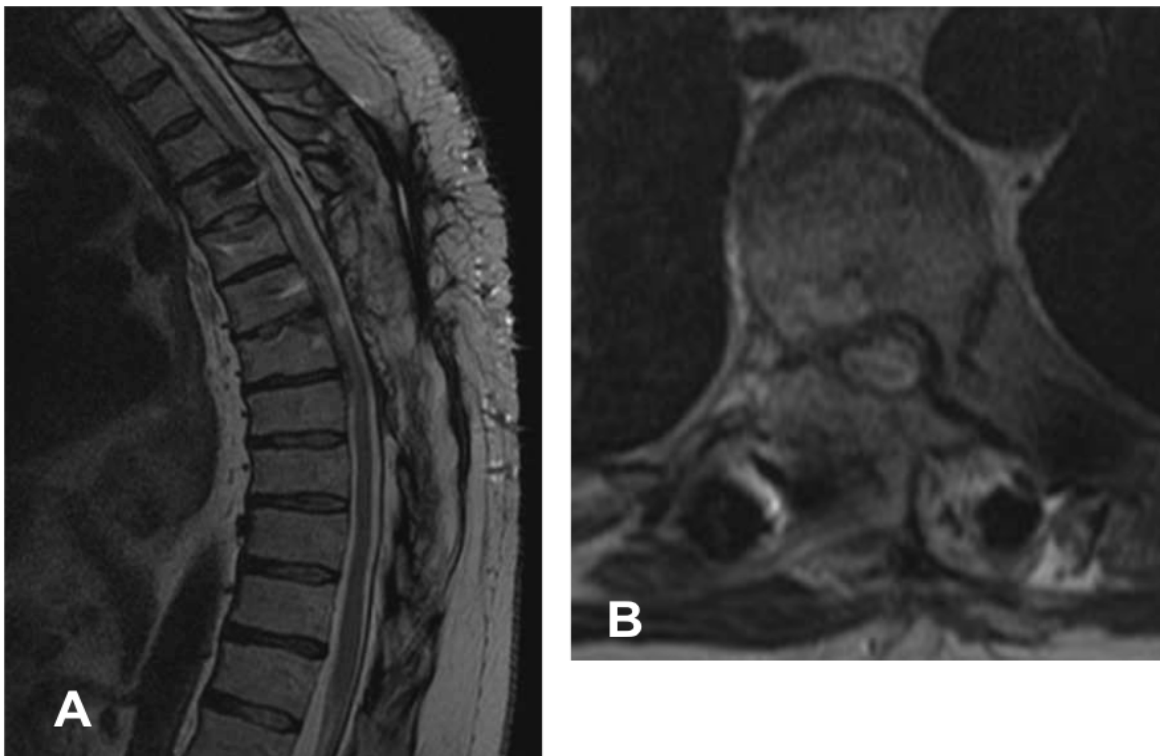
MRI of the spine, sagittal (A), and axial (B) section. Two years follow-up shows no evidence of local recurrence and satisfactory spinal cord decompression.
